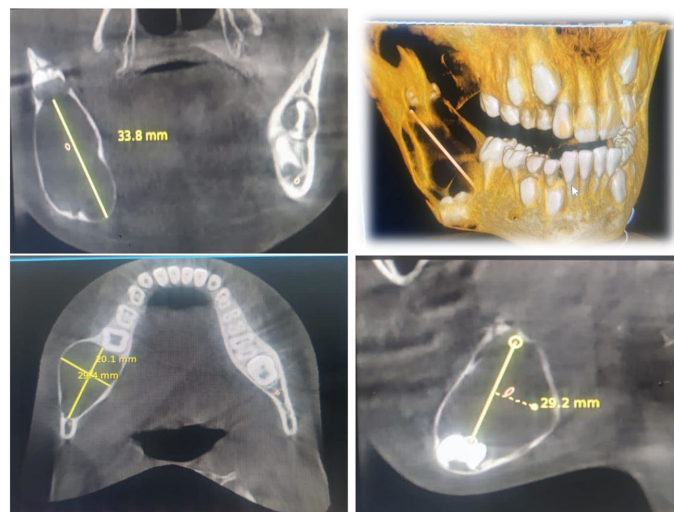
CBCT demonstrating the huge extension and thinning of the: buccal cortical expansion and thinning of the external and internal cortical tables
